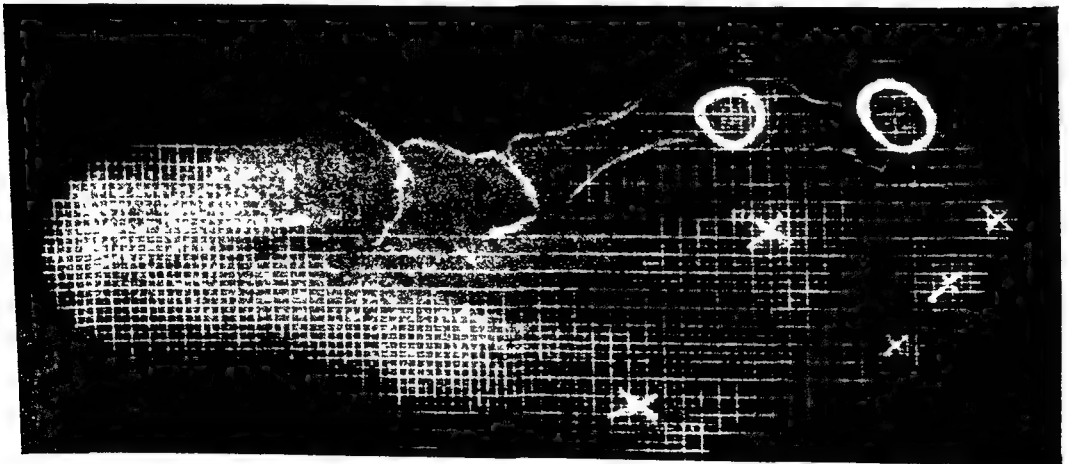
ORTHODYNAMIC RADIOGRAPH (X-RAY PAPER) Hallux valgus foot type excess imprint to medial sesamoid and interphalangeal joint area of great toe.
